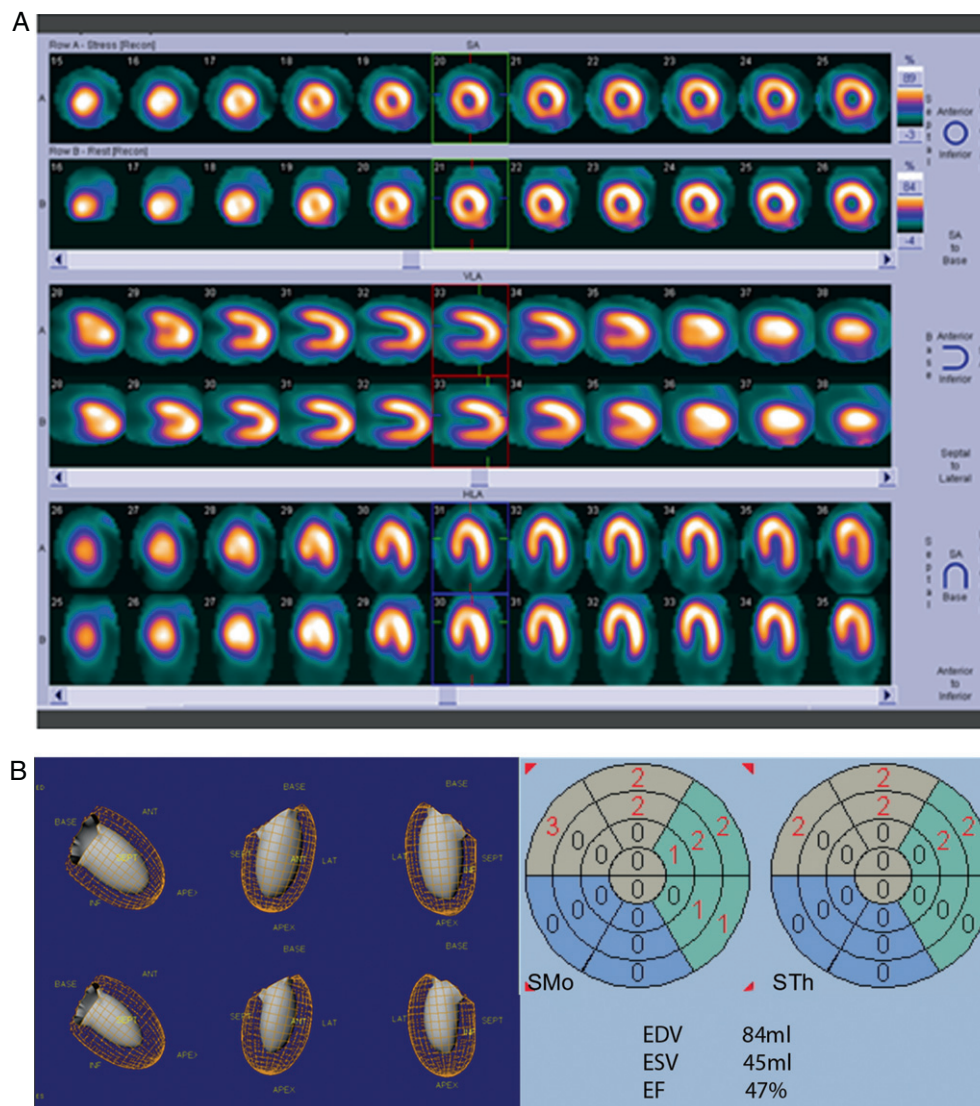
A) Myocardial perfusion SPECT image shows a normal perfusion pattern in a patient with ankylosing spondylitis. B) The semiquantitative analysis of the same patient's gated SPECT study reveals wall motion (SMo) and thickening (STh) abnormalities with scores calculated as 14 and 10, respectively. The calculated ejection fraction values was 47%.
